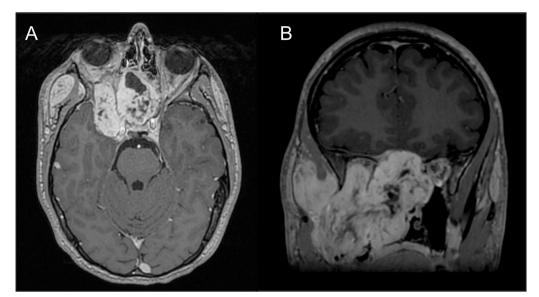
Axial (A) and coronal (B) contrast-enhanced T1-weighted MR images show that the juvenile nasopharyngeal angiofibroma invades the right orbital apex, contacting the optical nerve, and the right middle cranial fossa, contacting the cavernous sinus and internal carotid artery
